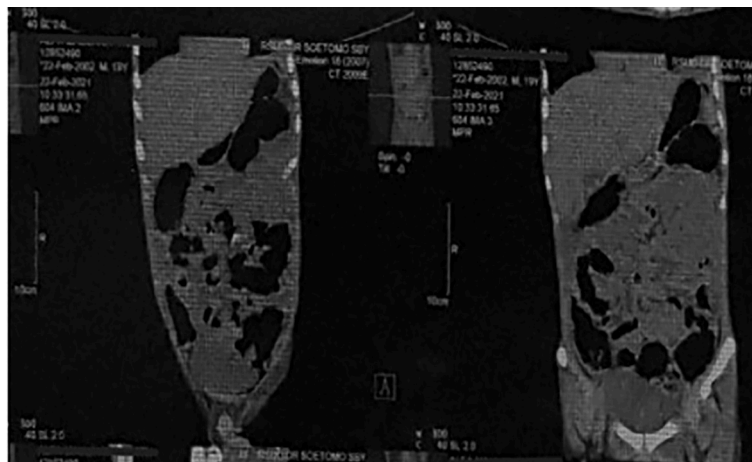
CT of the abdomen (coronal view) demonstrating densely-loculated ascites.
